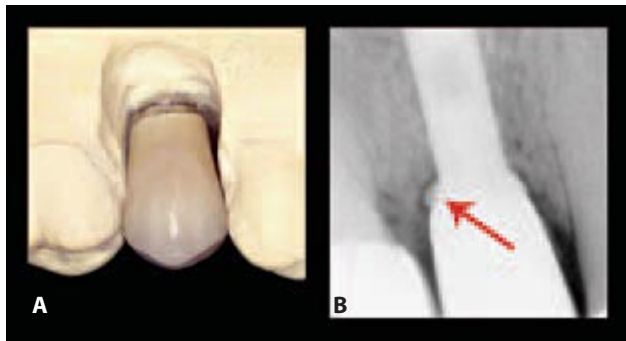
A. A deeply seated implant on the cast reveals a long crown margin that is impossible to be accessed for cleaning. B. A radiographic view shows the red arrow points at the excess luting cement being retained in the sulcus due to the difficulty to remove it.
